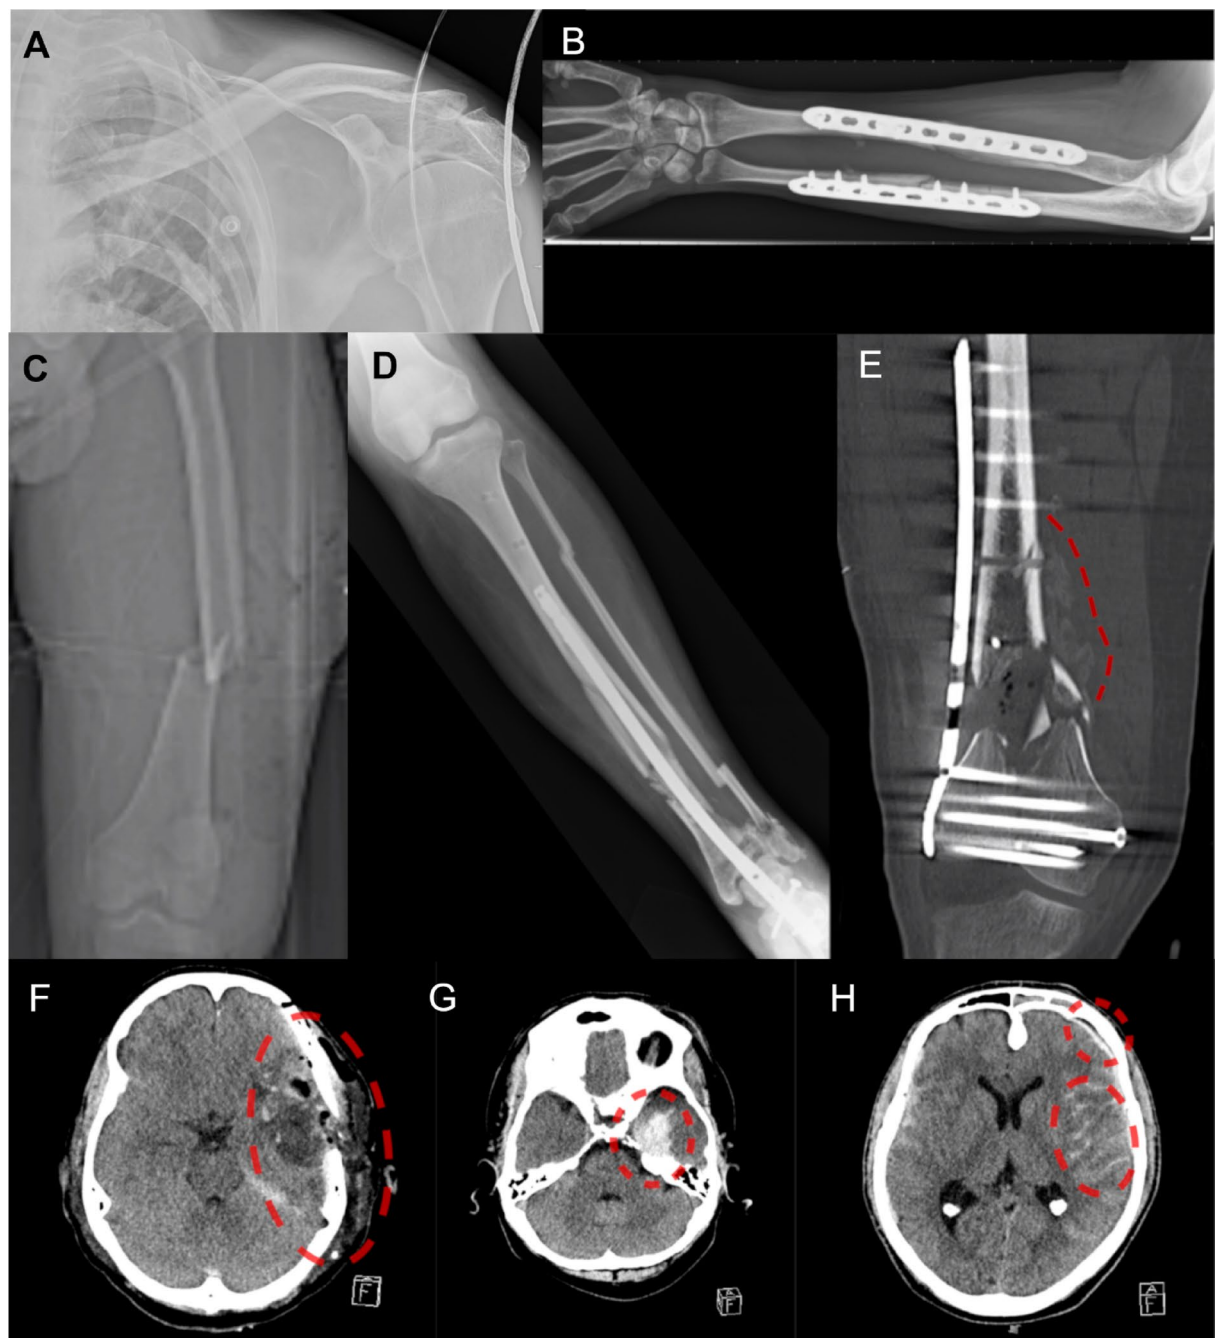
X-ray and CT images of injuries. Representative examples of injuries from patients included in the study. (A) Anterior–posterior (AP) X-ray of a lateral clavicle fracture (patient 019). (B) AP X-ray of a forearm fracture (radius and ulna; patient 016). (C) Frontal CT scan of a femoral shaft fracture (patient 006). (D) AP X-ray of an open tibial shaft fracture including the pilon (patient 029). (E) AP X-ray of an open distal femur fracture with hypertrophic callus marked with a red dashed line (patient 032). (F) TBI, SDH, ICH (patient 001). (G) TBI, SDH (patient 028). (H) TBI, SDH, SAH (patient 019). Head injuries in F, G and H are marked with red dashed circles.
